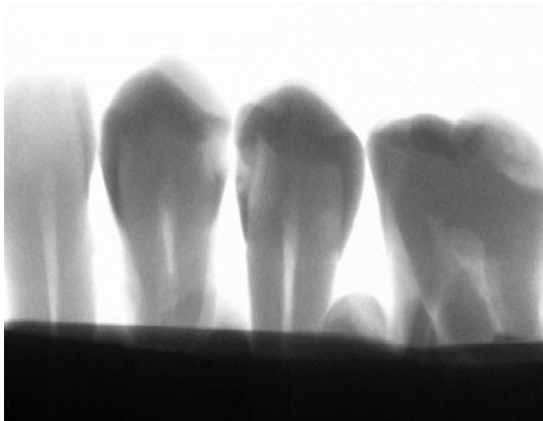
Application of the reverse contrast filter on the radiographs of the teeth
